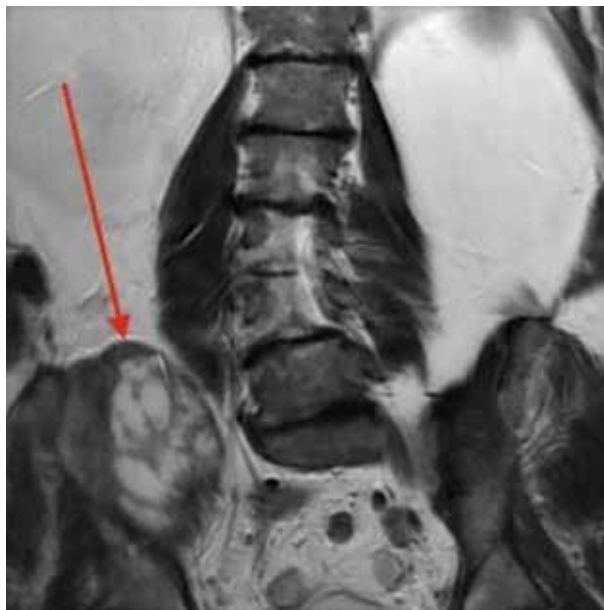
CT showing 3.7 x 2.6 x 7.5 cm abscess within the iliopsoas muscles.
